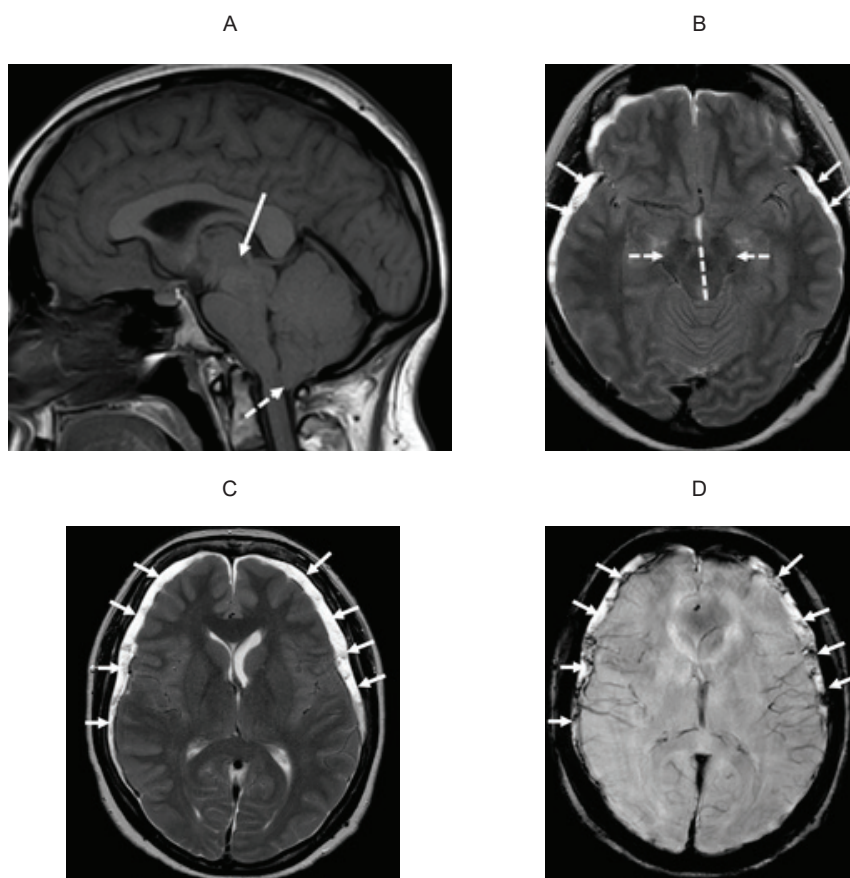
Barin MRI in intracranial hypotension (own observation): A – caudal displacement of the cerebellum (dashed arrow), stem structures and midbrain, with narrowing of the basal cisterns of the brain, deformation of the pons and cerebral peduncles (solid arrow) on T1-weighted sagittal images; B – subdural hygromas (solid arrows), “flattening” of the midbrain on the lateral sides with an increase in its anteroposterior size (dashed arrows) on T2-weighted axial images; C (T2 images), D (SWI mode) – subdural effusions with a slight accumulation of hemosiderin, which indicates previous subdural hemorrhages; significant narrowing (slit-like shape) of the lateral ventricles on axial images
